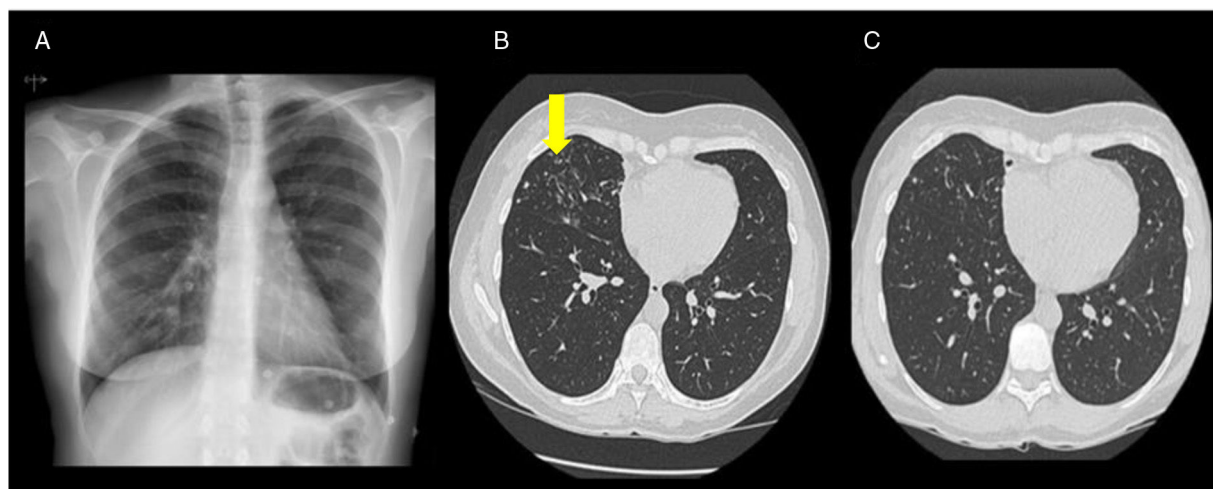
(A) Chest X-ray: parenchymal involvement in the middle lobe, with images that suggested a bronchiectasis. (B) Chest CT (before treatment): Volume loss with bilateral bronchiectasis and bronchiolectasis in the middle lobe and the lingula, several of them occupied with peribronchial thickening and tree-in-bud pattern. Small centrilobular nodules were detected, as well as some patchy areas. (C) Chest CT (after treatment): bronchiectasis and bronchiolectasis in the medial segment of the middle lobe. Improvement of the distal bronchiolar involvement in the pulmonary lobes previously described, in connection with a favorable evolution of the underlying infectious process.
